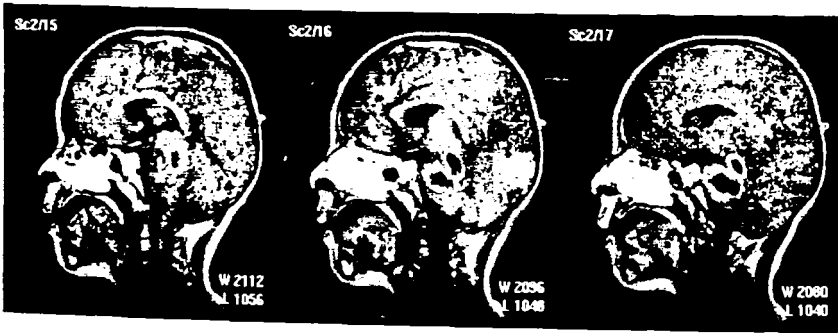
Preoperative, sagittal, precontrast serial MR images of the same patient
